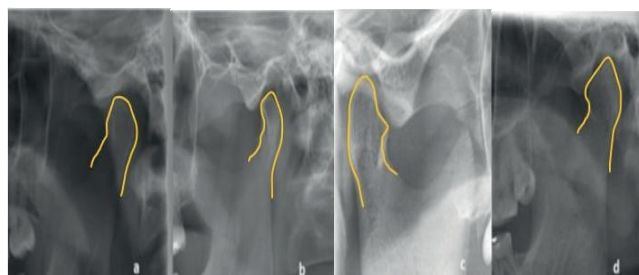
Types of condyle morphology on panoramic radiography. a. oval; b. crooked finger; c. bird beak; d. diagonal diamond
